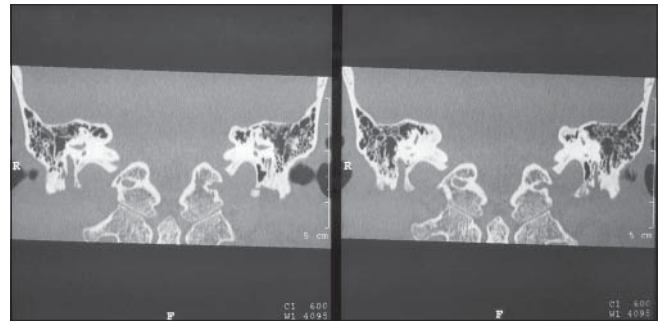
Coronal cut of contrast enhanced computed tomography showing ballooning and edema of vertical portion of facial nerve
